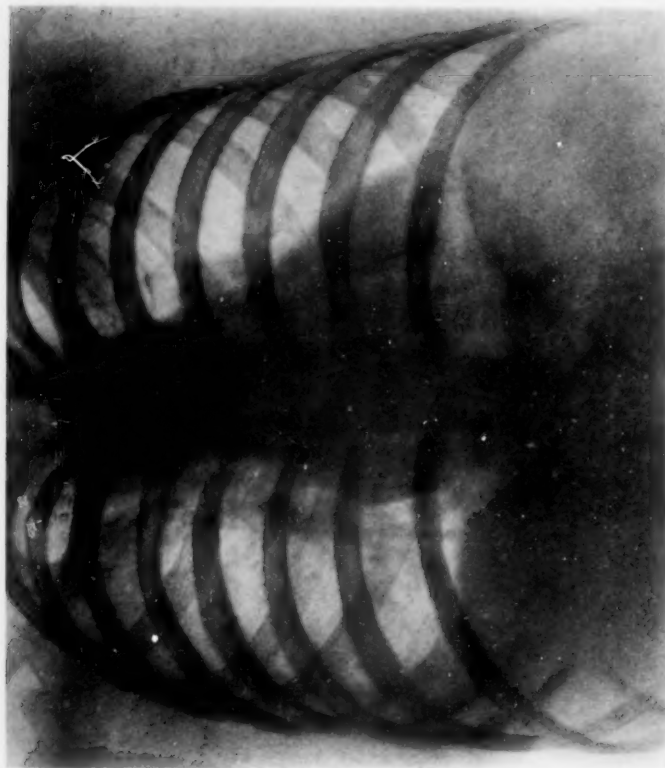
The end-result in the case shown in Fig. 3. (X-ray taken ten months after operation.) The cavity is obliterated. There is only a slight haziness to indicate what was found at operation to be a greatly thickened pleura.
